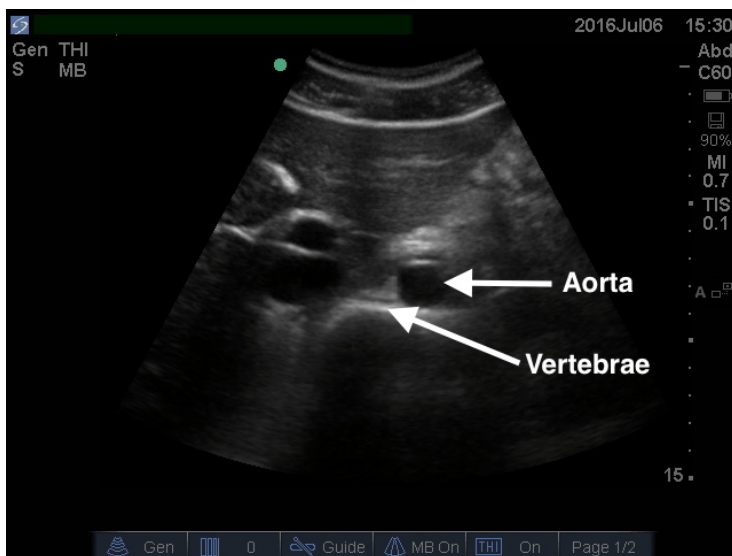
Transverse ultrasound of the aorta with landmark (anterior border of vertebrae).
